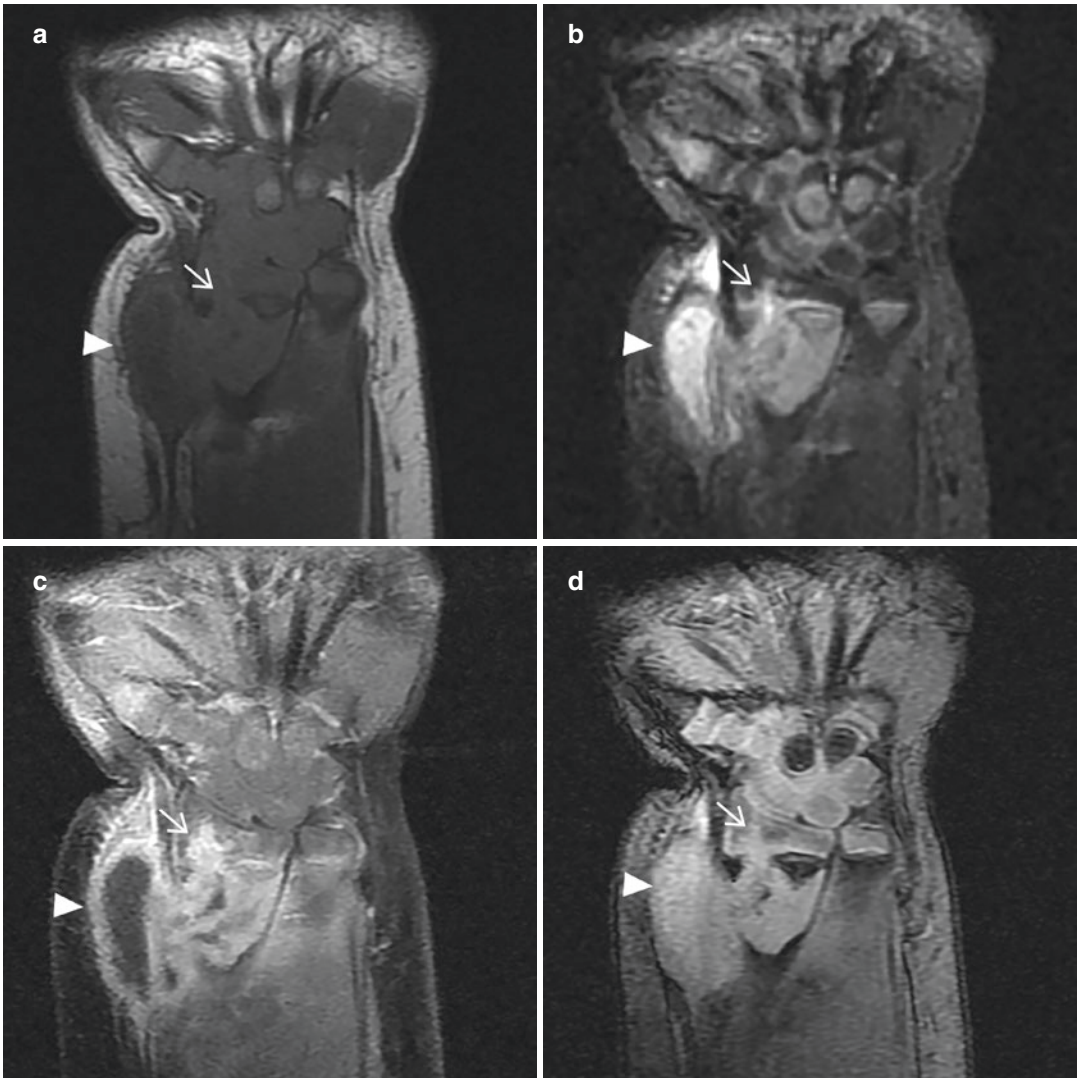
Tuberculous osteomyelitis with transphyseal spread in a 1-year-old girl who had wrist pain and swelling for 1 month. Coronal (a) T1-weighted, (b) STIR, (c) contrast-enhanced fat-suppressed T1-weighted, and (d) 3D spoiled gradient-recalled (SPGR) MR images show
